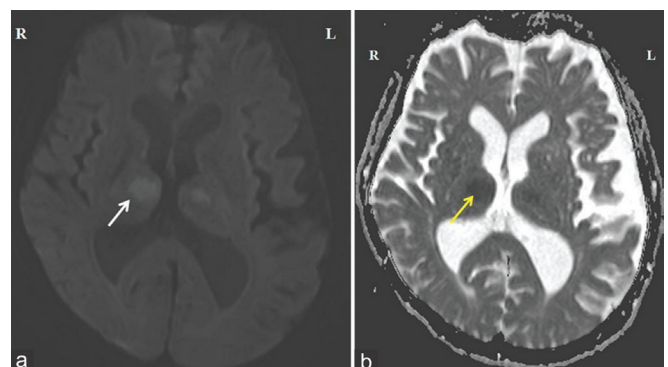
Magnetic resonance imaging of the brain showing focal areas of restricted diffusion in the medial part of the thalami bilaterally and in the rostral part of mid-brain (right > left). (a) Diffusion-weighted imaging sequence; (b) apparent diffusion co-efficient sequence
